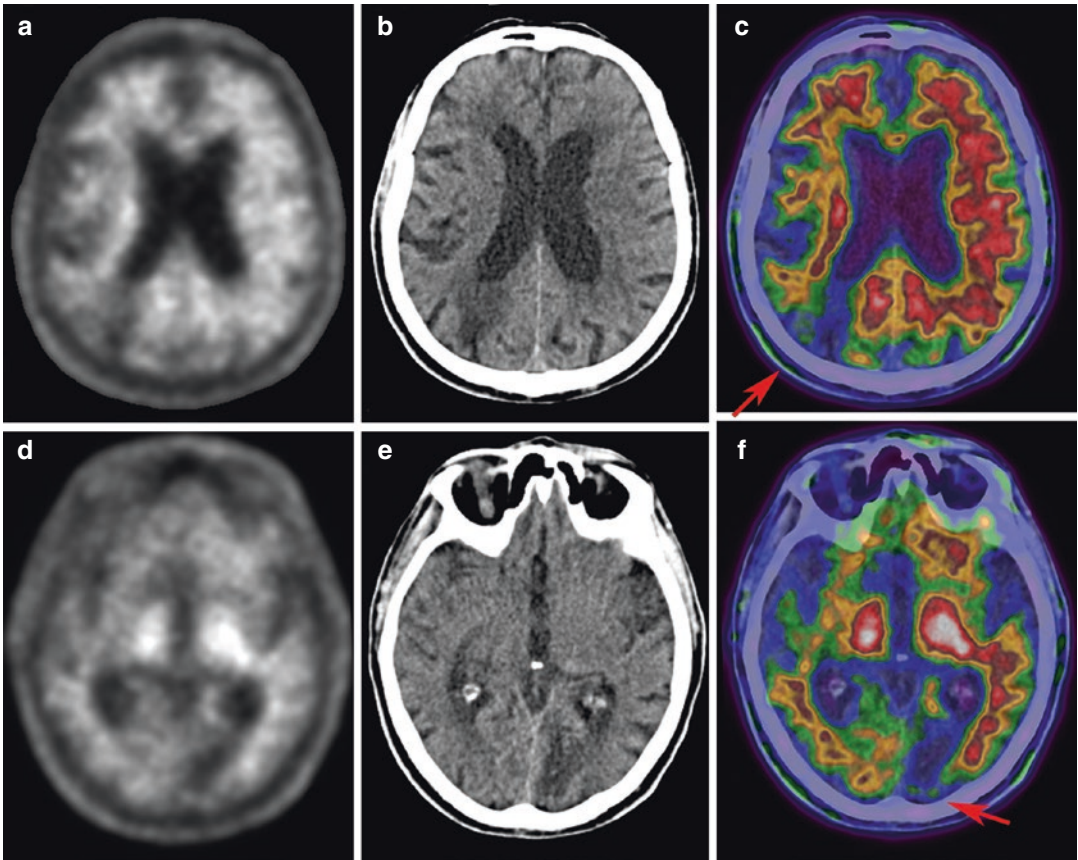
Axial ^{18}F -florbetaben PET (a), CT (b), and fused PET/CT (c) images showing no tracer uptake in a cortical-subcortical area of previous stroke in the right parietal lobe (arrow) in a 70-year-old male subject. In the same subject, another stroke was detectable in the left temporal and parietal lobe (d, e, f) with no significant uptake of the radiolabeled compound (f, arrow)
